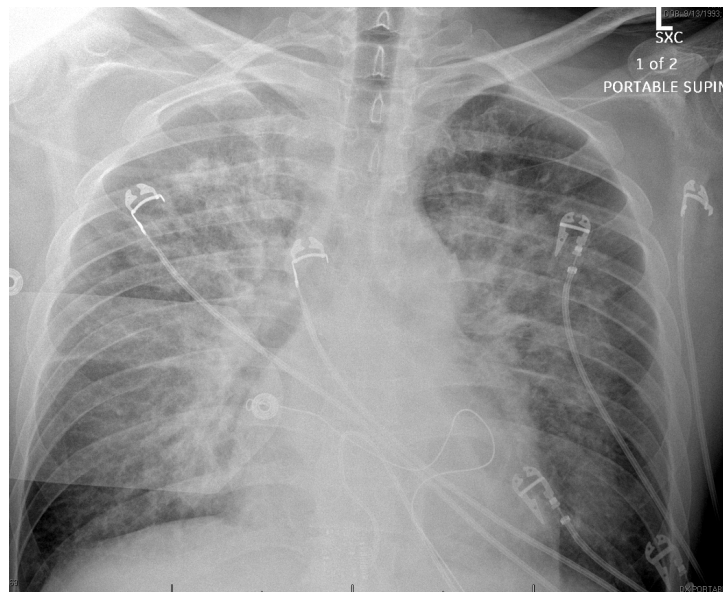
Chest x-ray obtained post-myocardial biopsy. Multifocal dense bilateral pulmonary opacities with small bilateral pleural effusions
